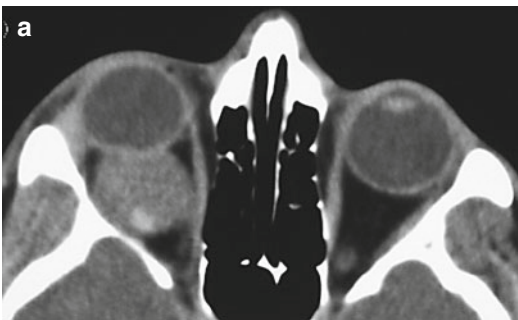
(a) CT image: right-sided cavernous hemangioma causing axial exophthalmos and showing calcification. (b) Facial photography
